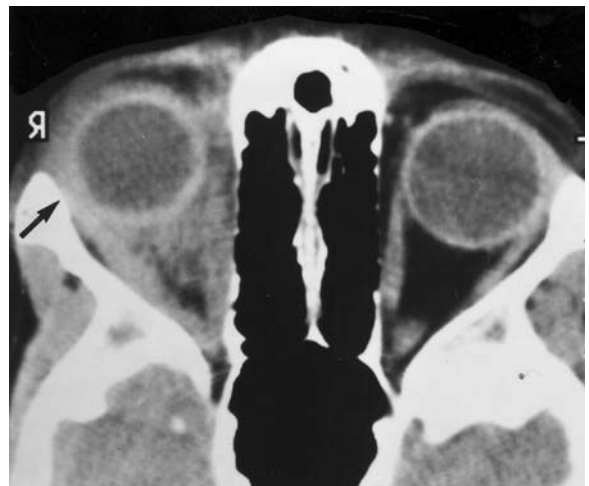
Axial CT of a 10-year-old girl with painful, progressive exophthalmos of the right eye. Diagnosis: diffuse idiopathic orbital inflammation. Diffuse scleral thickening of the entire circumference, distinct, hazy hyperdensity of the retrobulbar fat, diffuse swelling of the lateral rectus muscle, including the tendinous insertion (*arrow*), but not affecting adjacent structures. (With permission of MÜLLER-FORELL and LIEB 1995b)
